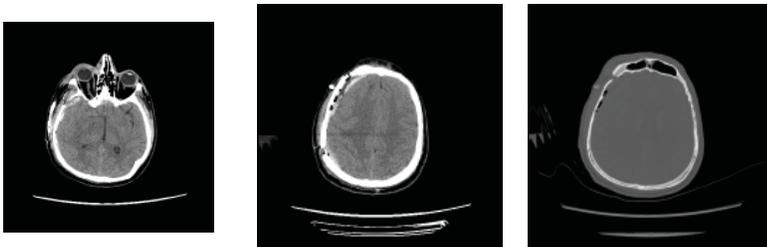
The follow up CT scan obtained in the first post-operative day. (a) Adequately removed temporal and occipital hematomas with no more mass effect on the ipsilateral ventricle, occipital horn started to appear after the evacuation of the hematoma. (b) After evacuating the frontal EDH no more midline shift or displacement of the falx. (c) Bone window demonstrating the size and extent of the craniotomy bone flap used for hematoma evacuation
